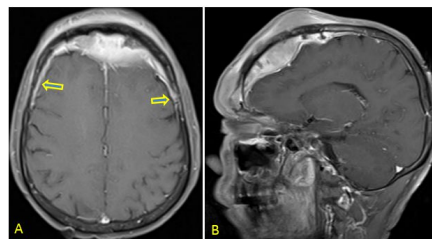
Post-contrast MRI Brain. A, Axial and B, Sagittal T1 FS Images shows diffuse enhancement in the tumor lesion with enhancement of the adjacent dura (arrow).
